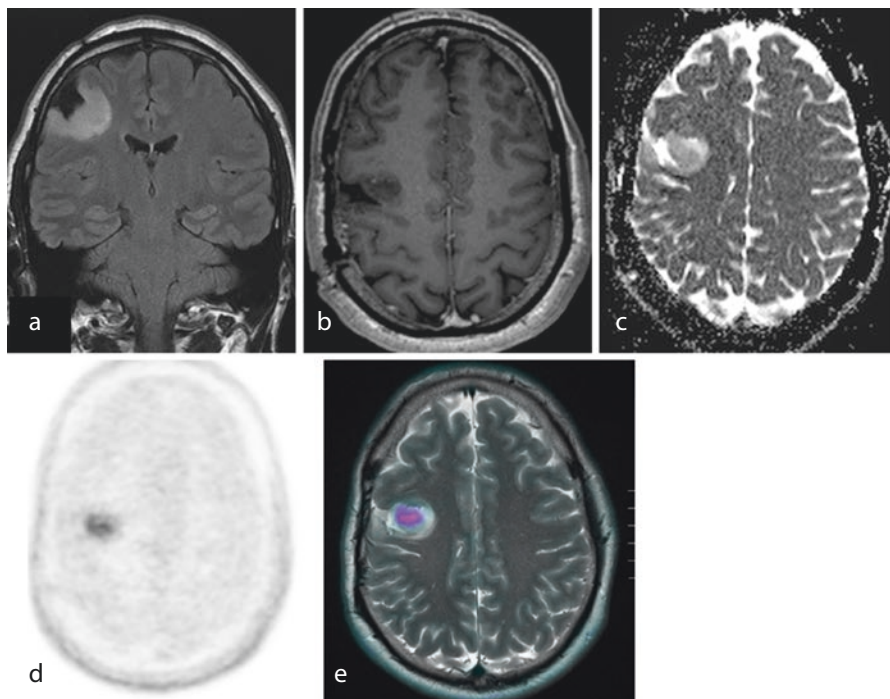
(a–d) Coronal T2W FLAIR (a), axial post-contrast T1WI (b), axial ADC map (c), axial ^{18}F DOPA PET (d) and axial fused ^{18}F DOPA PET/MR (e) demonstrate a high-signal, non-enhancing area in the right frontal lobe (a, b) with diffusion restriction (c) in a patient previously operated for a high-grade glioma tumour in the right frontal lobe with similar stable postoperative MR appearances compared to prior postoperative imaging over the last 4 years. However, further imaging with ^{18}F DOPA shows increased tracer uptake in the right frontal lobe tumour (d, e), consistent with active residual disease. The patient had further treatment 2 weeks later which demonstrated active tumour which was completely removed.
